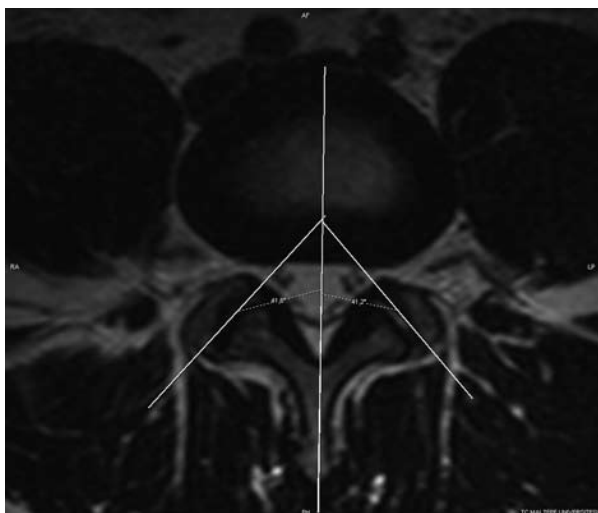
Axial MRI scans (T2-weighted TSE) demonstrates the measurement of the facet joint angles in this study at a disc level. On the left side angle is measured as 41° to the midsagittal plane and on the right angle is 41° to the midsagittal plane.
